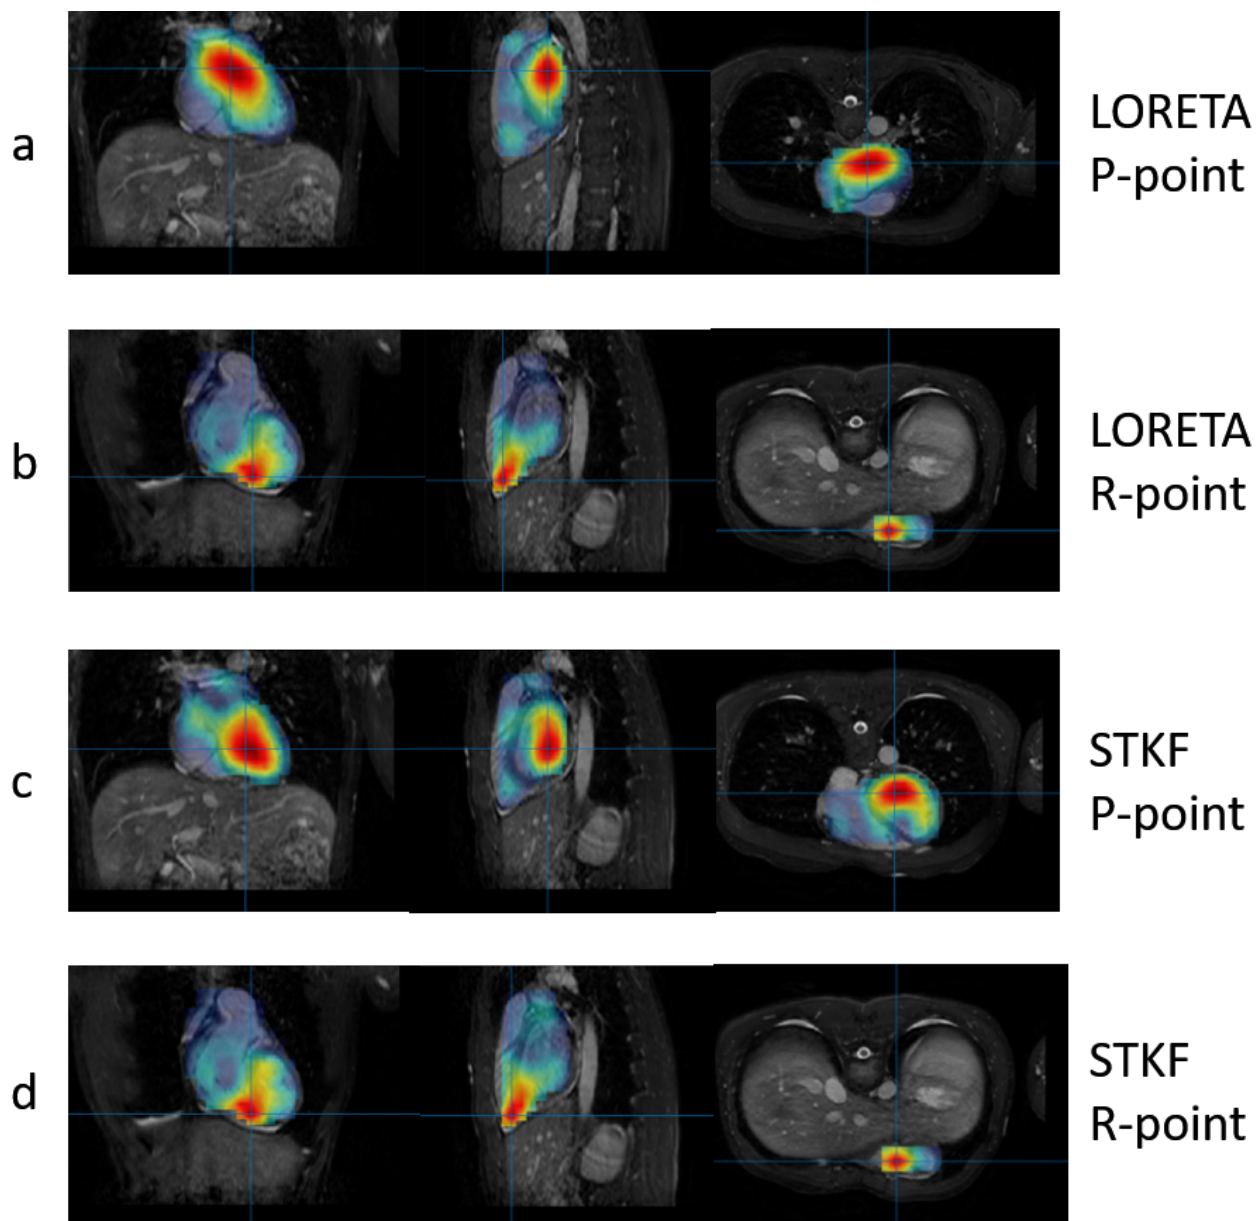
The source imaging results from the second dataset using LORETA and STKF at two time points of interest on the heartbeat cycle, namely the P-point and the R-point. The source activity results are superimposed on the MRI to show the heart activity in accordance with the heart anatomy.
